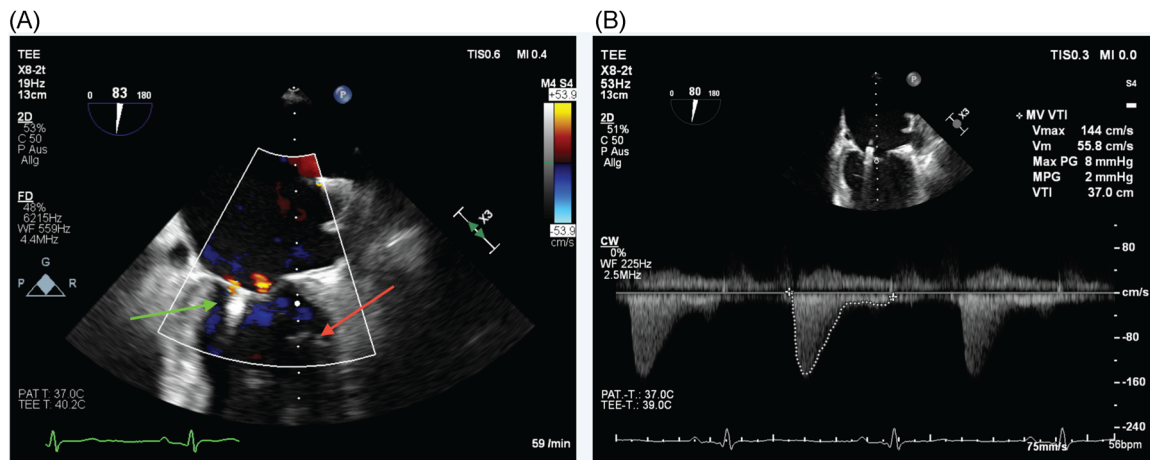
Postoperative results. (A) Postoperative transesophageal echocardiography (TEE) showing remaining trivial mitral regurgitation after the MitraClip delivery (green arrow). The red arrow points to the Impella 5.5 echocardiographic shadow in the left ventricular cavity. (B) Postoperative flow profiles through the mitral valve
